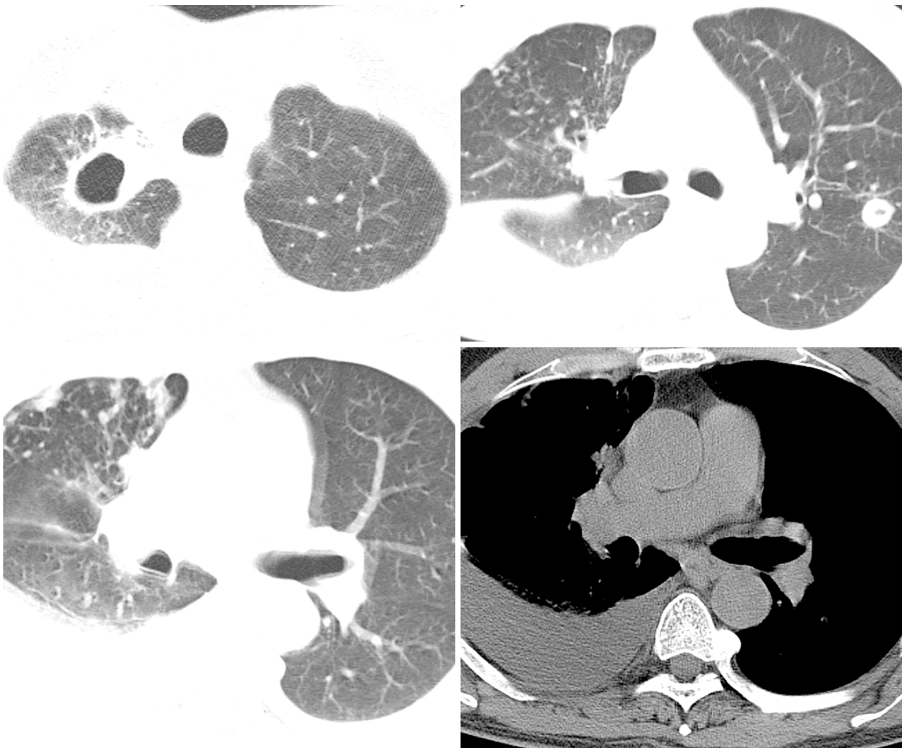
After admission, the computed tomography scan unveiled multiple nodules and cavities in both lungs, suggesting infection, particularly tuberculosis. Right pleurisy and pleural effusion were noted.
